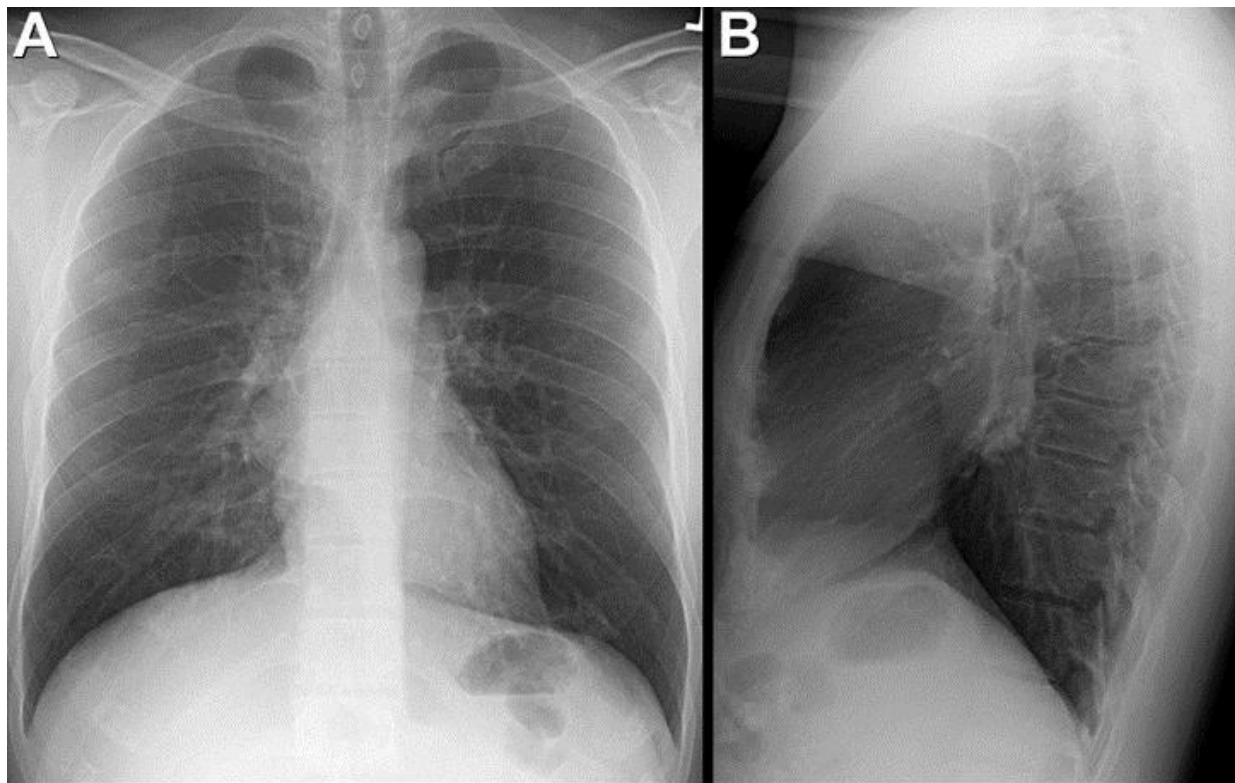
Frontal (A) and lateral (B) chest radiography.
